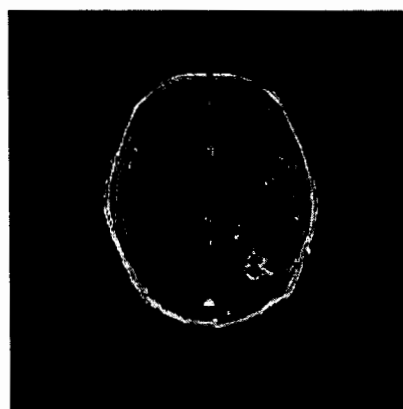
Registered MR image of brain with CT by Image Registration by Huang et.al
